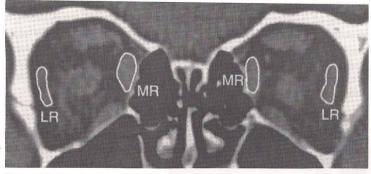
211 μ m resolution, 1 mm thick coronal CT scan of the orbits of a 5 year old girl with large "V" esotropia and marked overelevation and underdepression of the right eye in adduction. Note inferior displacement of right LR more than left LR.
